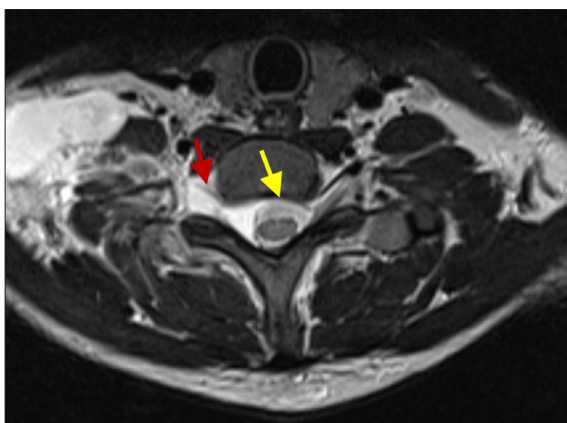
Brachial plexus MRI (T2 sequence, axial plane) revealing pseudomeningoceles (red arrow) and spinal cord deviation to the left at C7-D1 level (yellow arrow), without evidence of signal alterations of the spinal cord.
